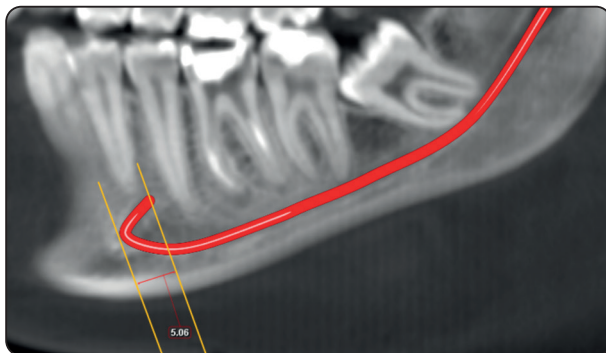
CBCT sagittal view showing the anterior loop (AL) length of the inferior alveolar nerve (IAN).
